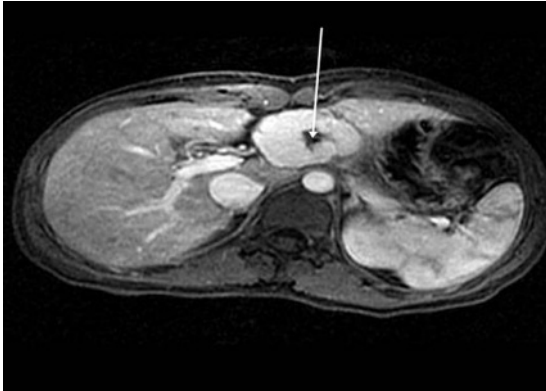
Left lobe focal nodular hyperplasia on delayed (1 h post-contrast) magnetic resonance image—retained enhancement around prominent central scar (arrow).
